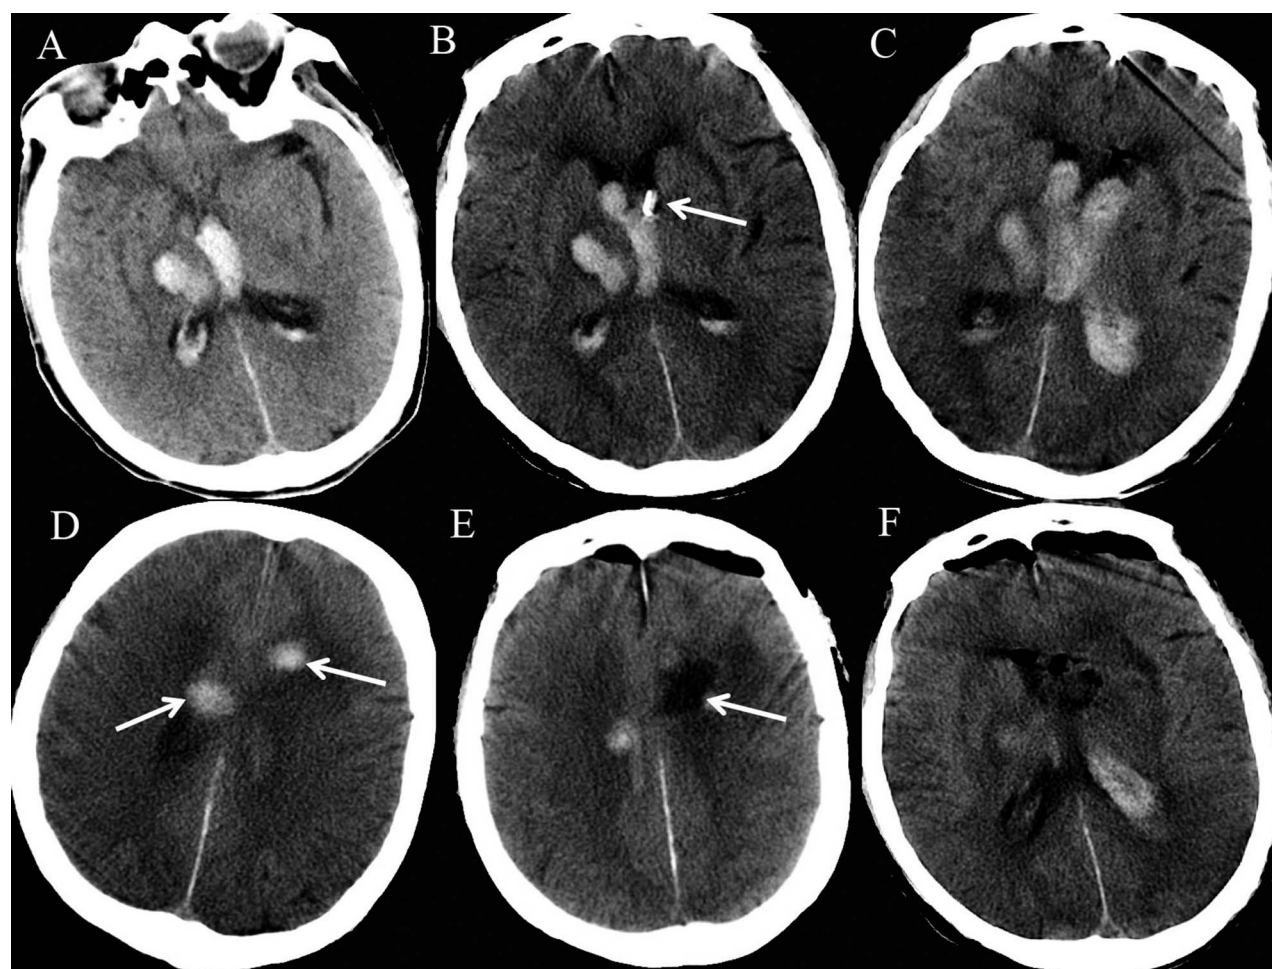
(A) Axial CT imaging displaying right thalamic hematoma extending into lateral and third ventricles. (B) Axial CT imaging 1 day after EVD displaying the catheter tip was in the lateral ventricle (arrow). (C, D) Axial CT imaging displaying acute ventricular hemorrhage cast immediately after removing bilateral drains. The fresh hematoma was spreading along the trajectory tracts (arrows). (E, F) Axial CT imaging displaying a large part of the hematoma was removed via the left frontal transcortical approach (arrow).
